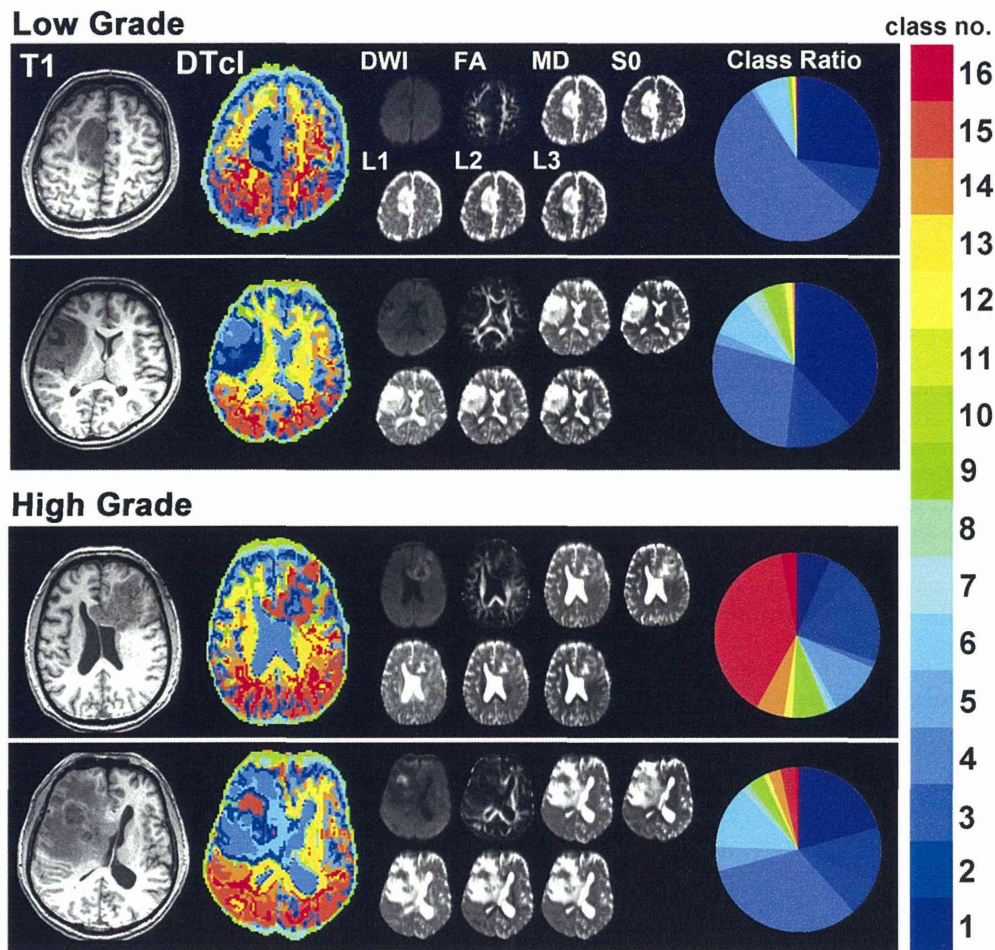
The representative cases of low- (upper) and high- (lower) grade gliomas, including the 16-class DTcls that showed the highest classification performance. The T1-weighted images, DTcls, seven diffusion tensor images and the ratios in each class number are shown for each patient. DWI = diffusion-weighted imaging; FA = fractional anisotropy; L1 = first eigenvalue; L2 = second eigenvalue; L3 = third eigenvalue; MD = mean diffusivity; S0 = raw T2 signal without diffusion weighting. Each colour on DTcls and circular charts correspond to each class number, shown in the colour bar.
